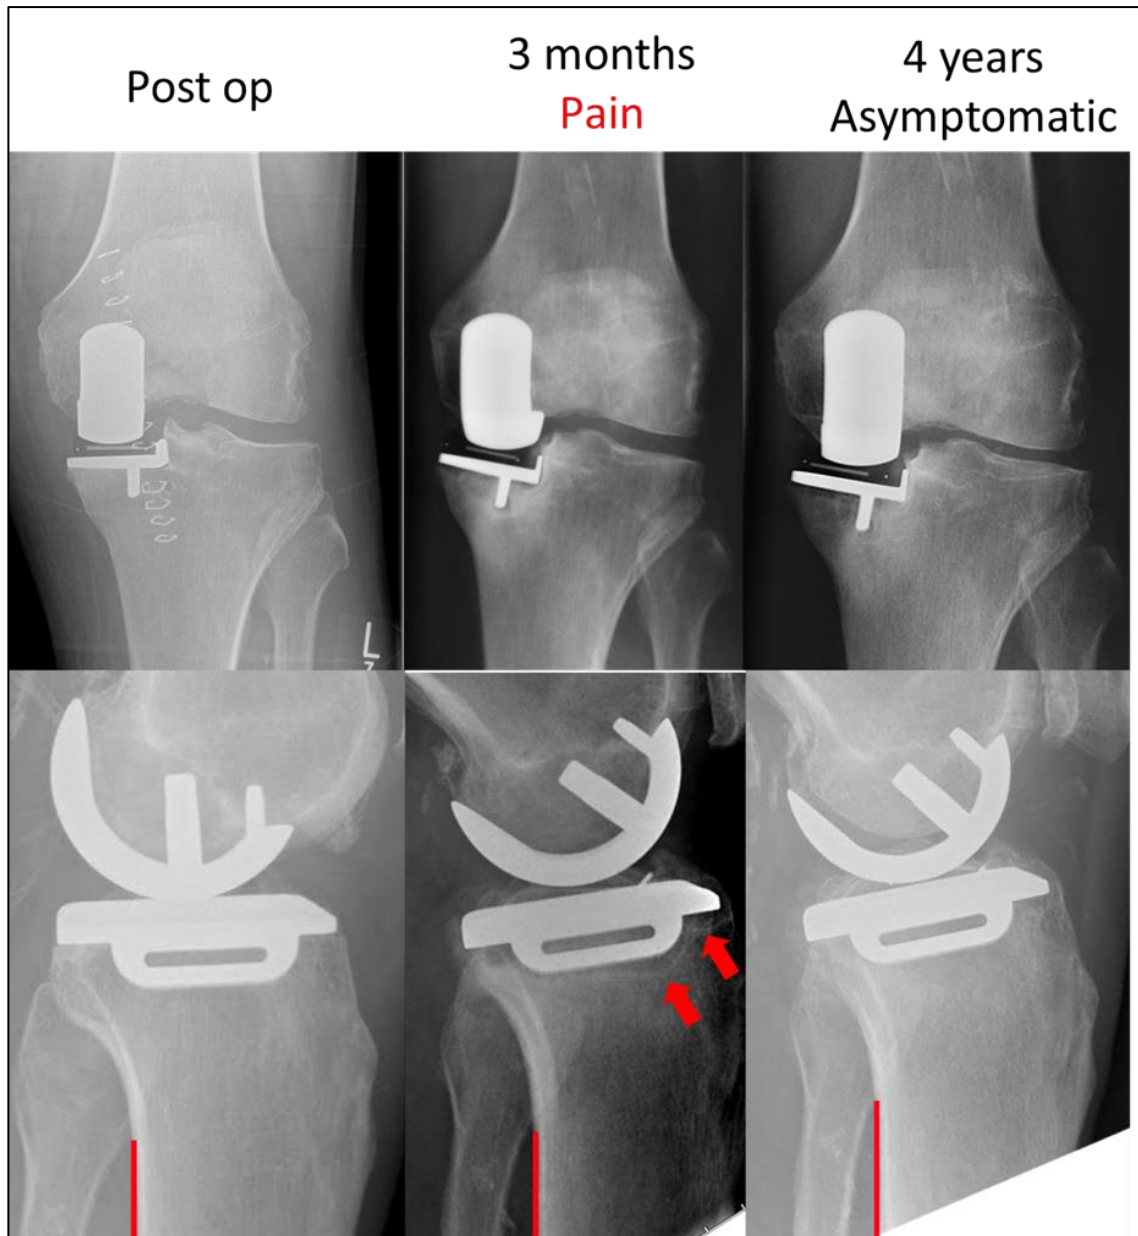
Example of Tibial Component Subsidence (TCS) with valgus rotation (see anteroposterior radiographs, top row) and posterior tilting (see lateral radiographs, bottom row) of the component that has occurred within 3 months of the operation. An anterior radiolucency accompanying the posterior tilting can be seen on the lateral radiograph, indicated by red arrows. TCS has been observed in a small number of patients with the cementless Oxford Unicompartmental Knee Replacement (OUKR) and has been reported to often be accompanied by pain in the early post-operative period.
